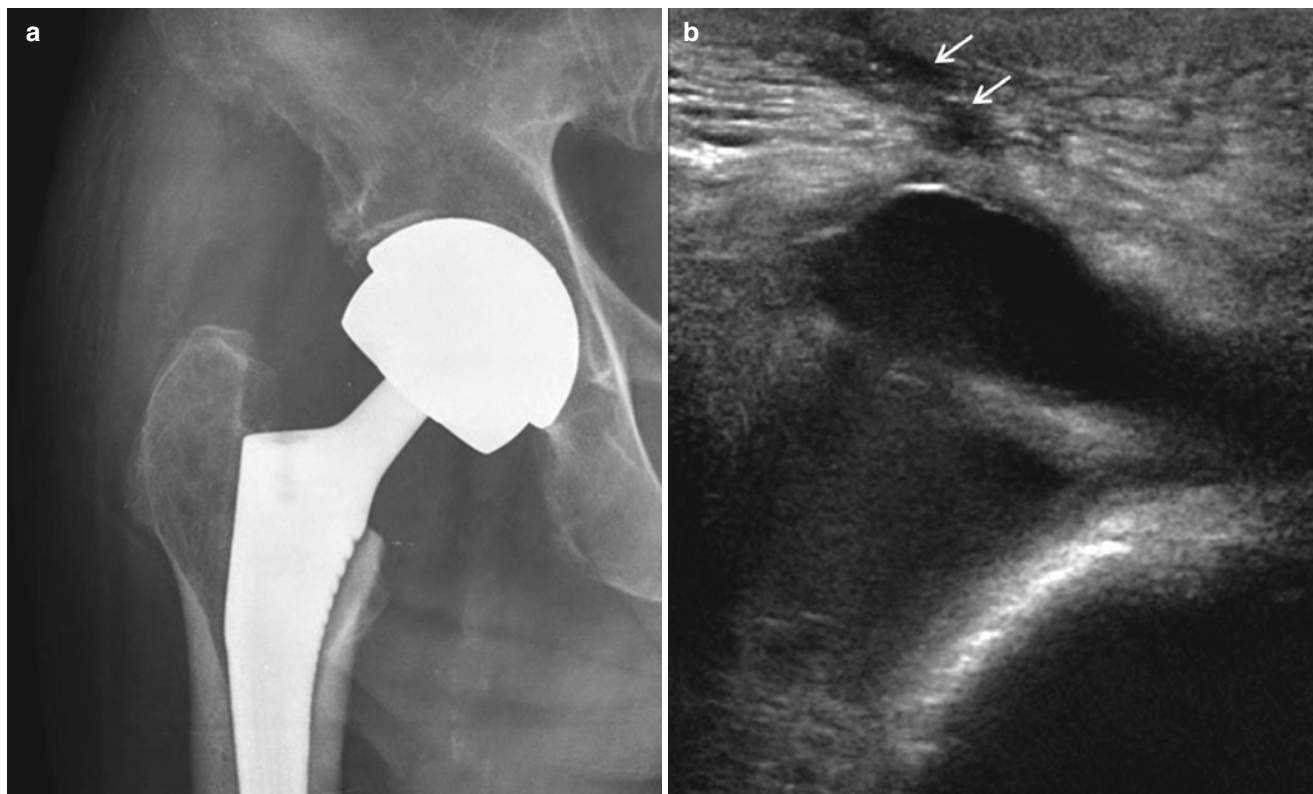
Infected arthroplasty in an 84-year-old patient. (a) Hip anteroposterior view demonstrates soft tissue edema at lateral aspect of right hip without osseous abnormality. (b) On ultrasonography, large
